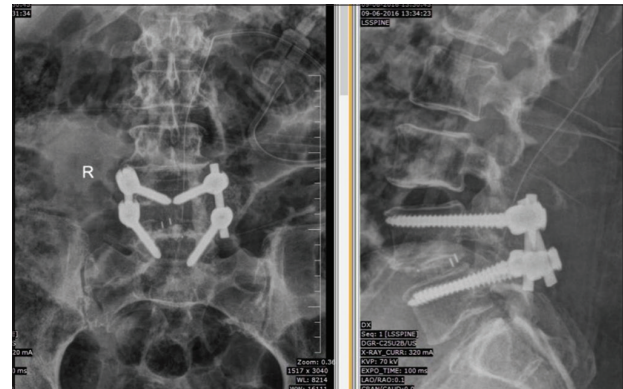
Postoperative anteroposterior and lateral X-rays on follow-up showing interbody cage, rods, and pedicle screws between L4-L5 (TLIF L4-L5) of patient 1.
